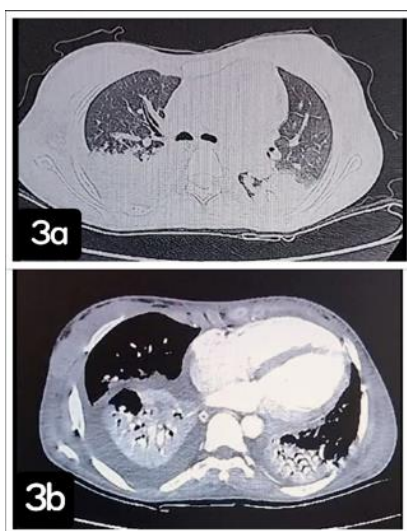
a and b: CT thorax indicative of bilateral pleural effusion, consolidation, GGOs, and cardiomegaly suggestive of pulmonary edema.
